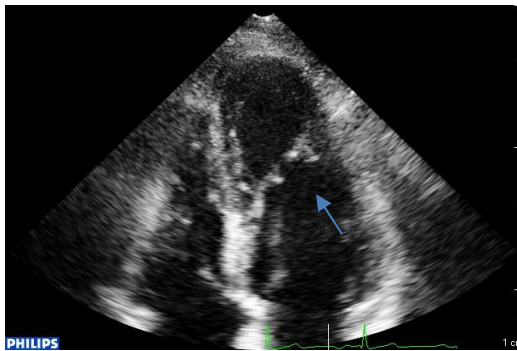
Ventricular band in apical four-chamber view
